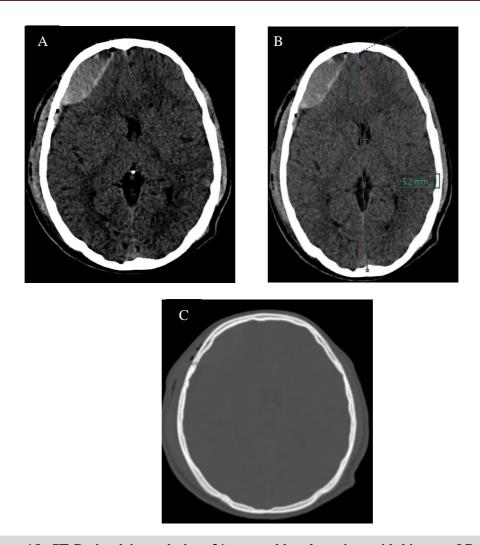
CT Brain plain study in a 21 years old male patient with history of Road traffic accident showing Extradural haemorrhage in right frontal region (A) with a midline shift of 5.2 mm towards left side (B) and fracture of right frontal bone (C)
